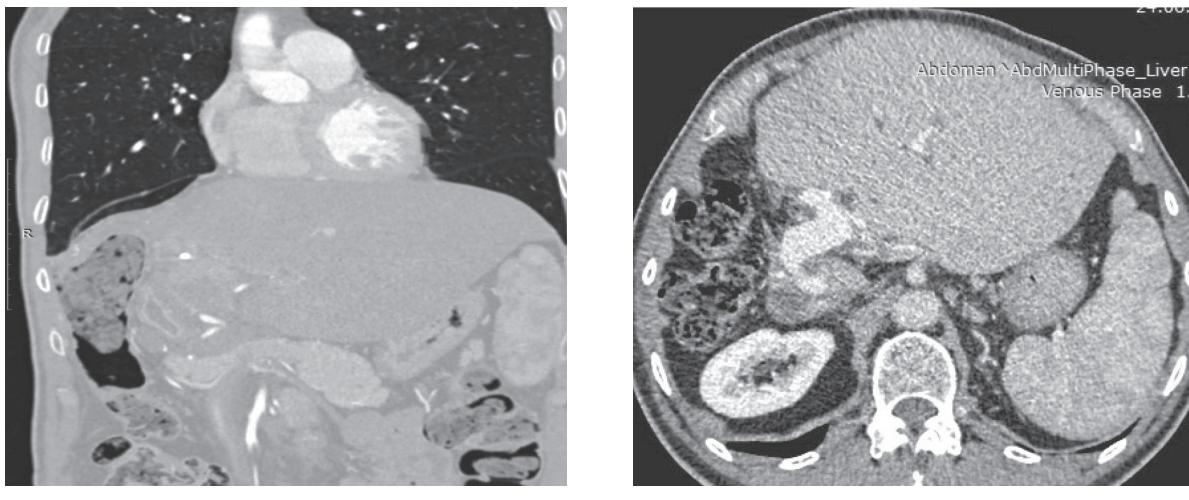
Control CT with intravenous contrast. Absence of relapse of the disease: A — a year after the operation; B — two years after the operation
